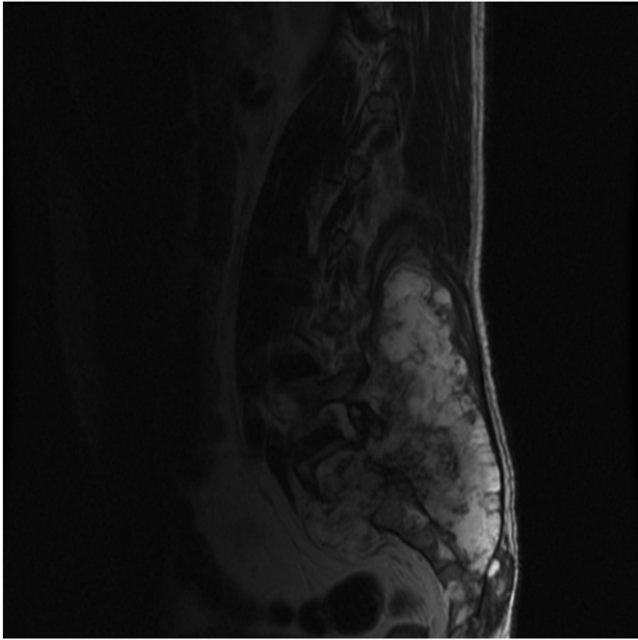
Preoperative T2 sagittal magnetic resonance image of the lumbosacral spine, demonstrating a large heterogeneous sacral mass.
